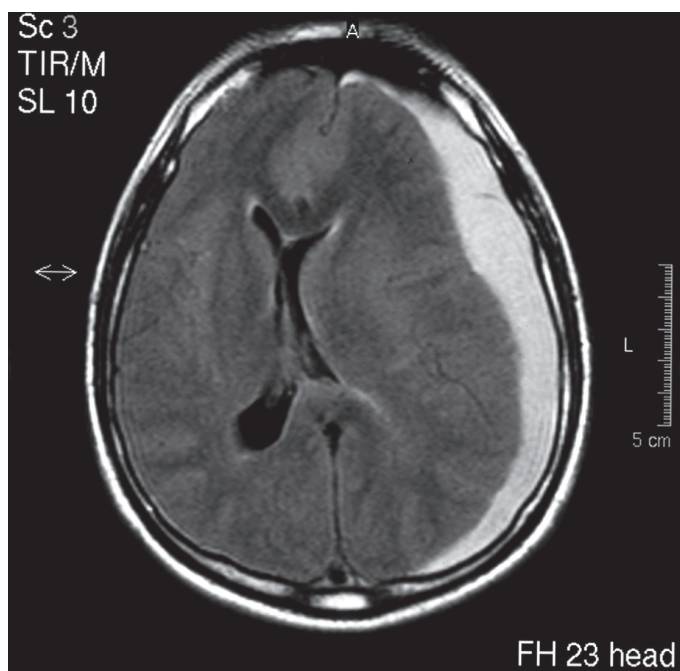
Cranial magnetic resonance imaging scan on the 45th postoperative day showing a 2.0 cm thick left-sided subacute subdural haematoma with 1.7 cm right midline shift.
